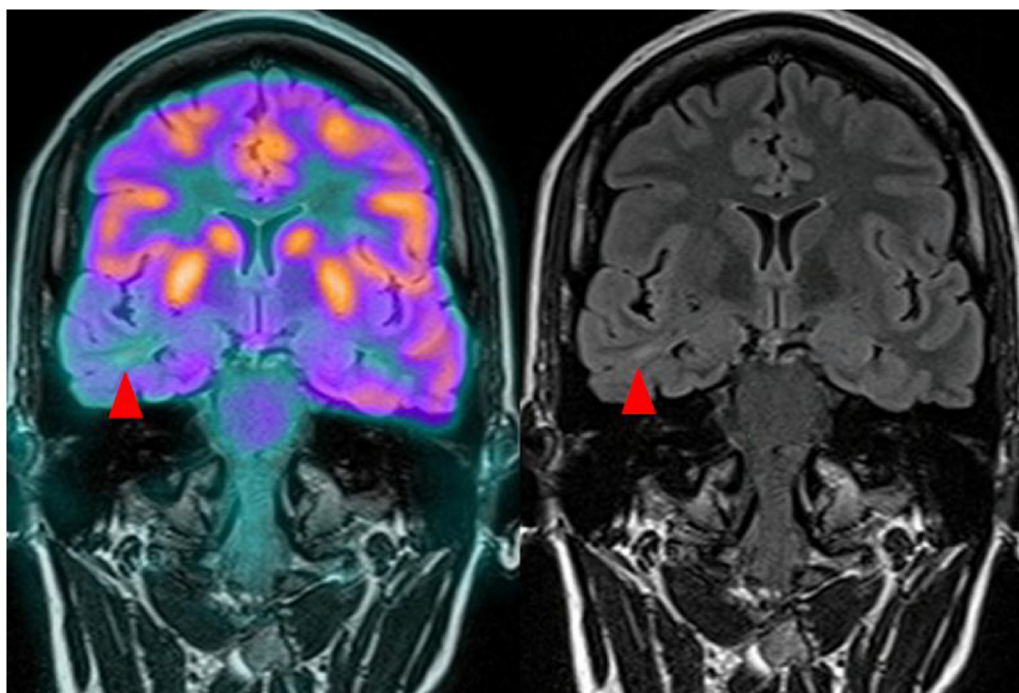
Diffuse cortical dysplasia was visible on both MRI and PET. The patient’s seizures resolved after resection of the abnormal right temporal lobe (red arrowheads). Mesial temporal sclerosis was found as well at pathology, not identified on MR (Case #21). (For interpretation of the references to colour in the text, the reader is referred to the web version of this article.)
